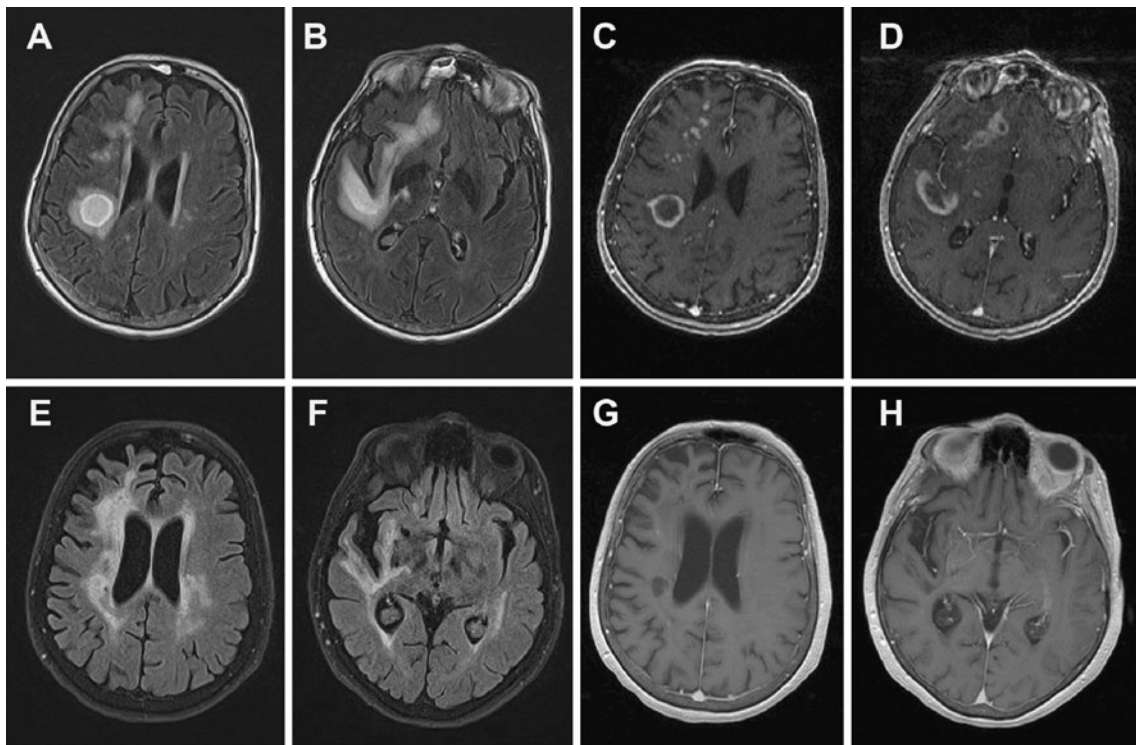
MRI brain. Initial presentation (*top row*): axial FLAIR showing tumefactive lesion in the right frontal lobe white matter extending to the subcortical white matter of the temporal lobe (a and b), axial T1+ gadolinium showing ring enhancement of the lesions (c and d). Ten-month follow-up (*bottom row*): axial FLAIR showed
